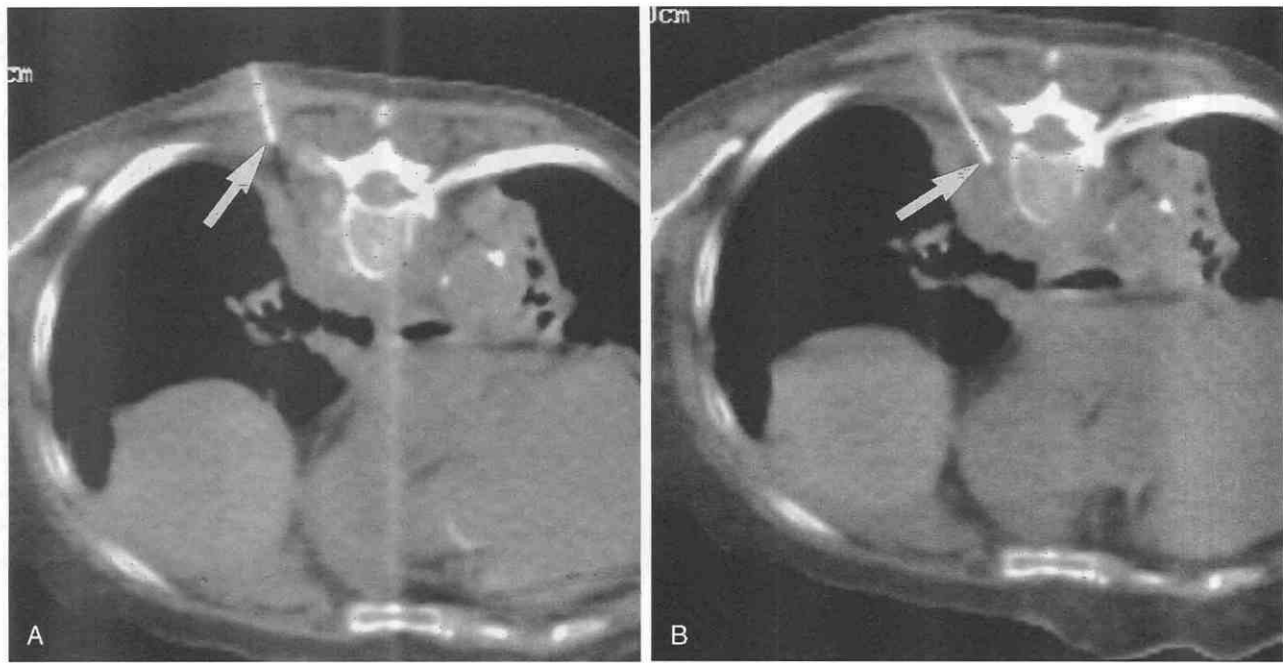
Biopsy of a left paraspinal soft tissue mass. CT fluoroscopy images demonstrate advancement of biopsy needle with changes in needle orientation and depth from A to B (arrows). CT fluoroscopy allows the changes to be made in real time. The pathologic process was bacterial osteomyelitis.
